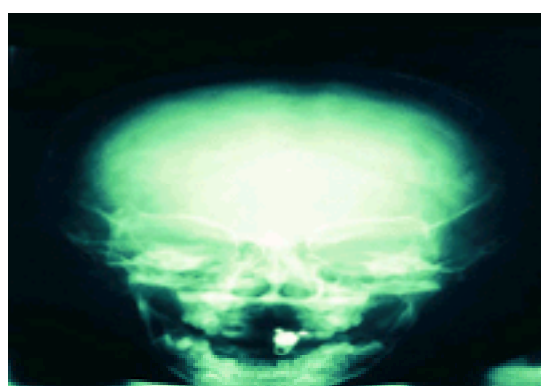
Radiograph of the skull to show separation of the skull sutures due to raised intracranial pressure in childhood.
